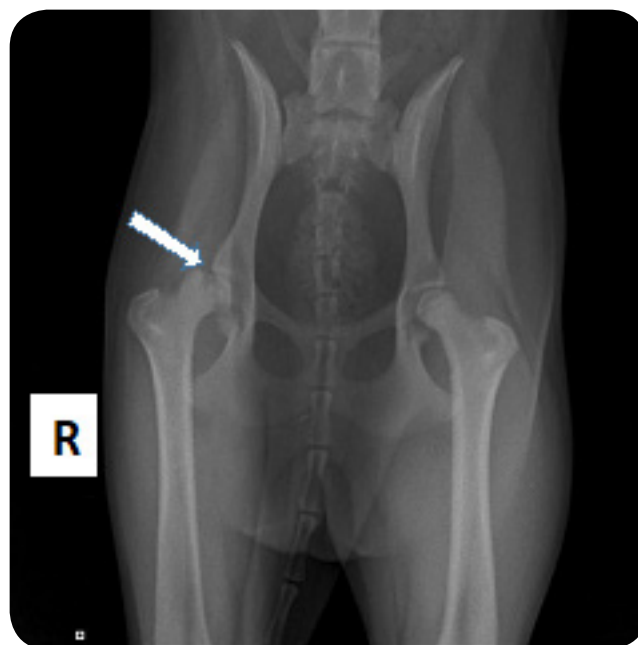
Ventrodorsal pelvic radiograph showing deformation of the right femoral head, widening of the right coxo-femoral joint space, and radiolucency in the right femoral head (white arrow).
